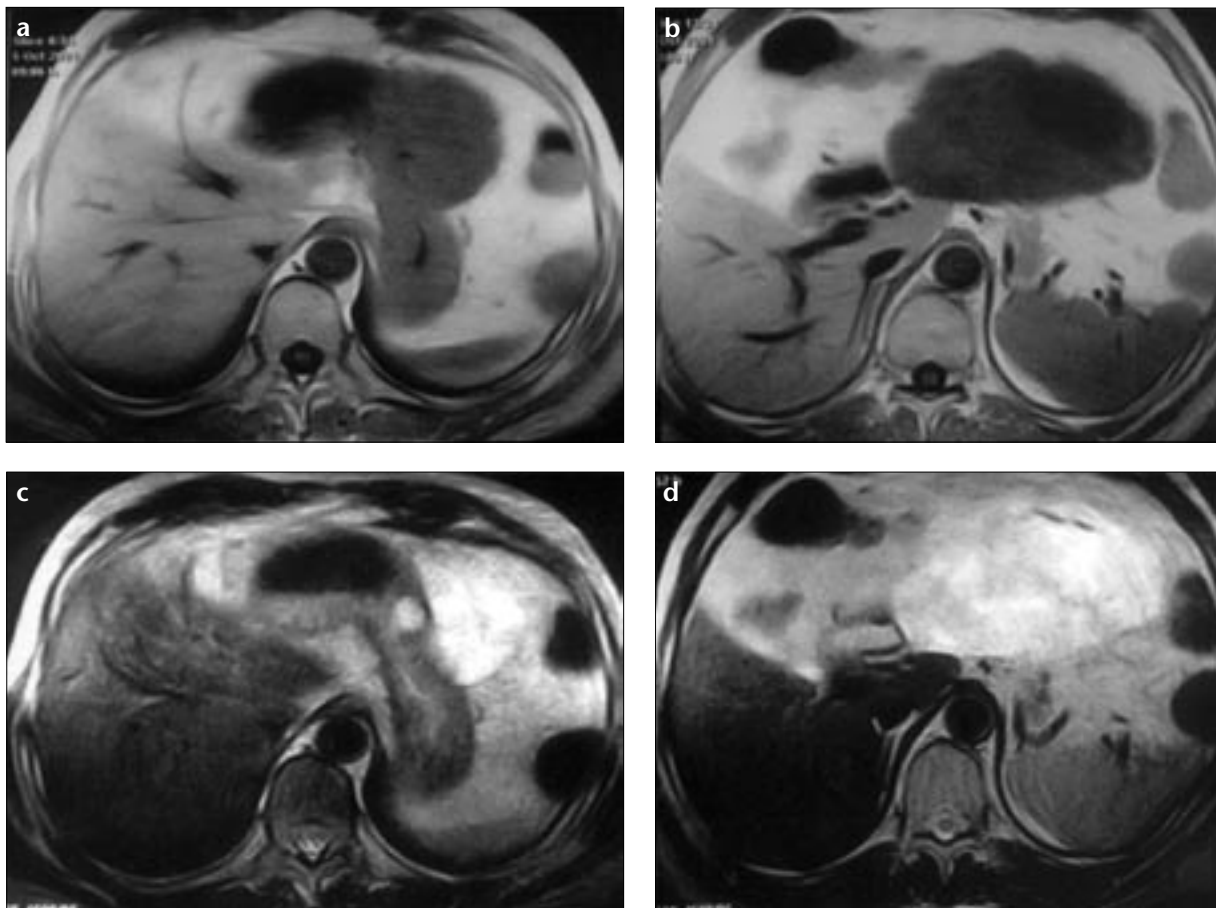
a-d. Transverse precontrast T1-weighted (a, b) and T2-weighted (c, d) MR images show an exophytic gastric mass, which is hypo- and hyperintense in relation to the stomach on T1- and T2-weighted images, respectively.
